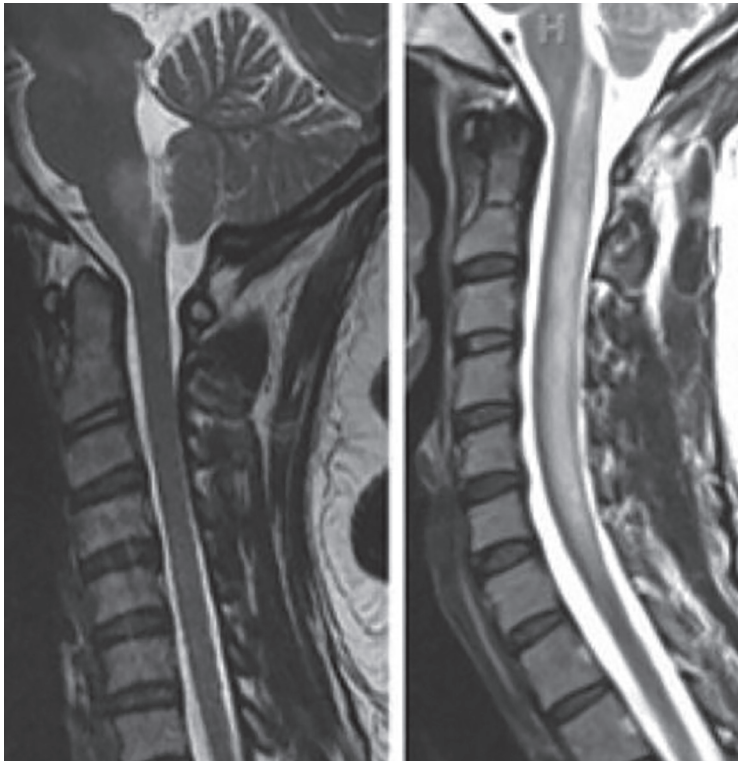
MRI showing a case of transverse myelitis; please note the severe swelling of the spinal cord, affecting the entire cervical spine.
